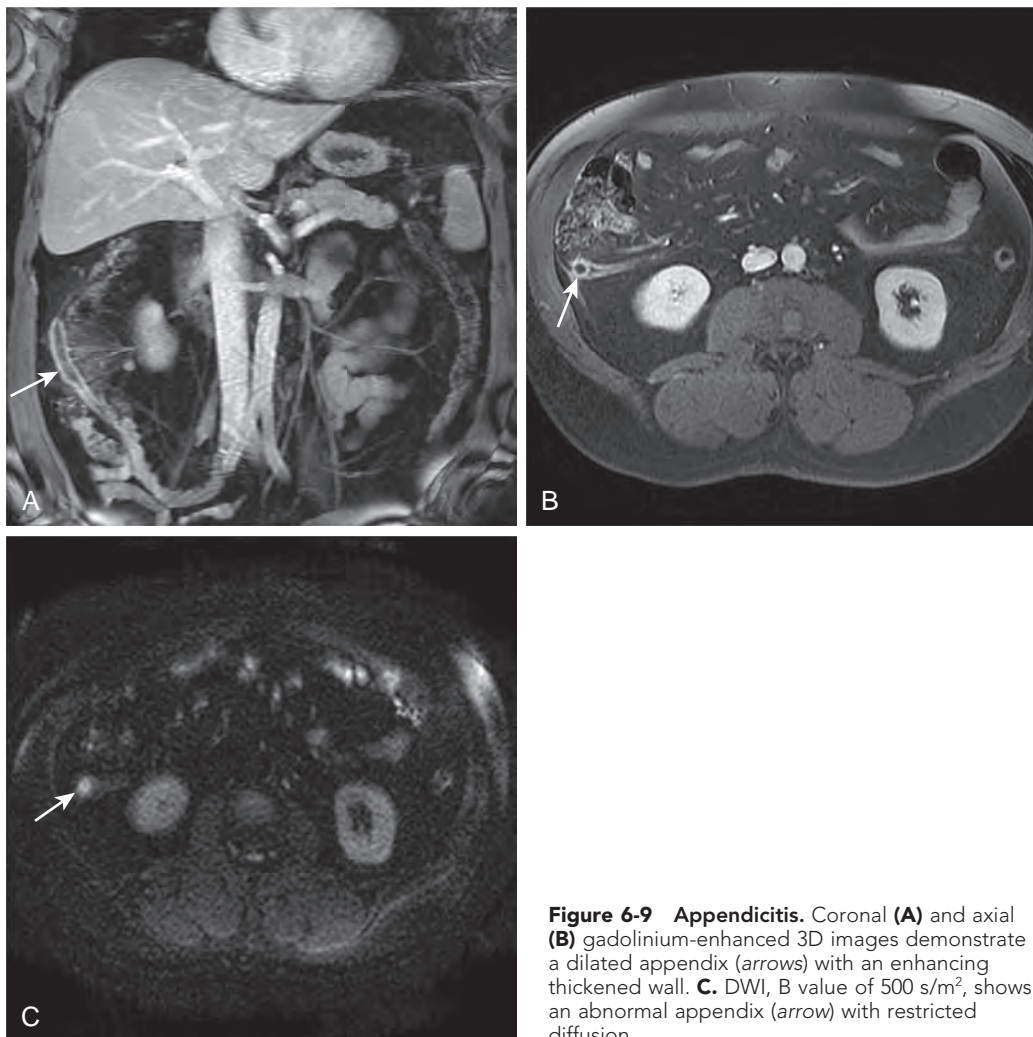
Appendicitis. Coronal (A) and axial (B) gadolinium-enhanced 3D images demonstrate a dilated appendix (arrows) with an enhancing thickened wall. C. DWI, B value of 500 s/m², shows an abnormal appendix (arrow) with restricted diffusion.
